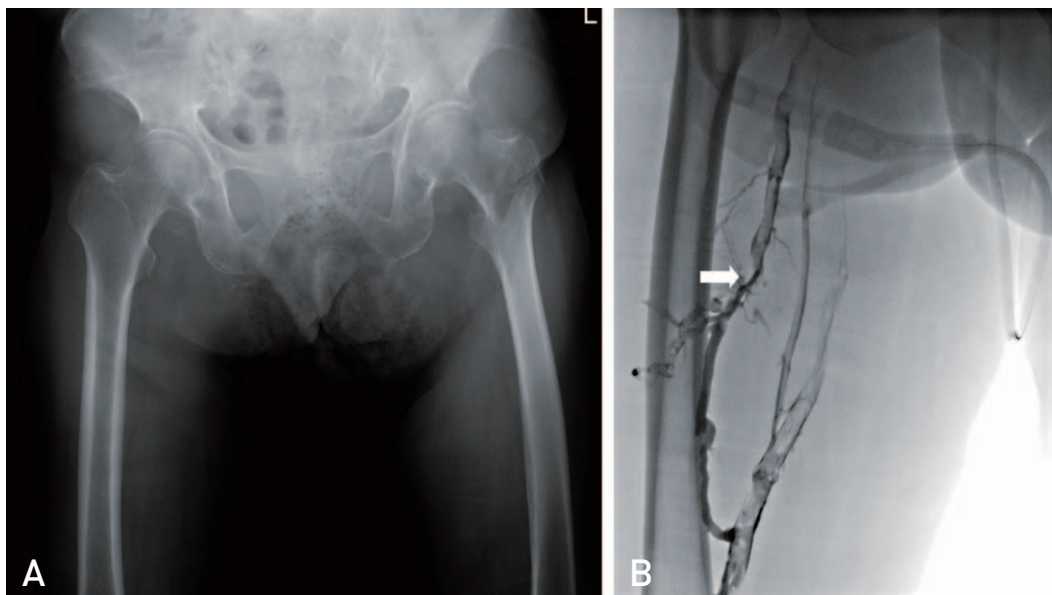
(A) This plain radiograph showed an intertrochanteric femoral fracture in a 77-year-old women. (B) The venography was performed due to suspicion of deep vein thrombosis. The narrowing of deep femoral vein was observed because of deep vein thrombosis (arrow).
